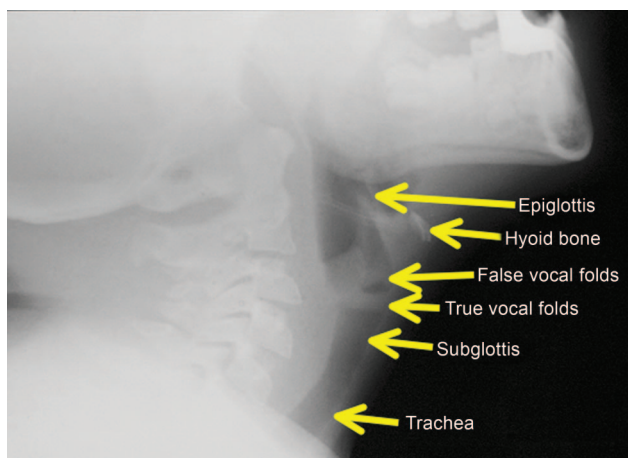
Lateral neck radiograph; anatomic structures are labeled.
